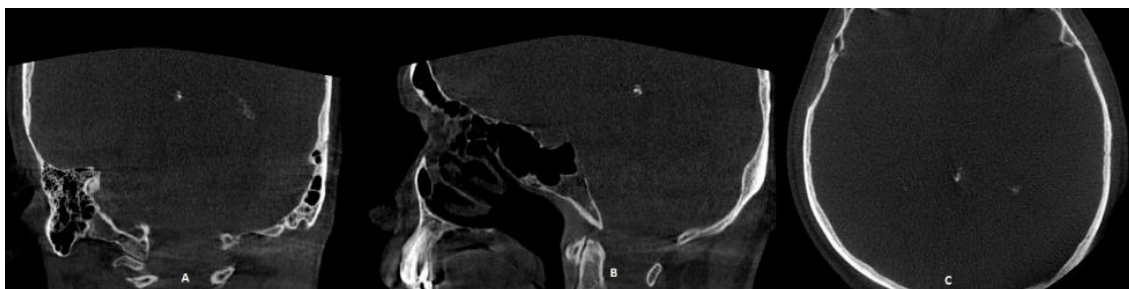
CBCT sections A. Coronal, B. Sagittal C. Axial CBCT sections showing intracranial calcification of Internal carotid artery
